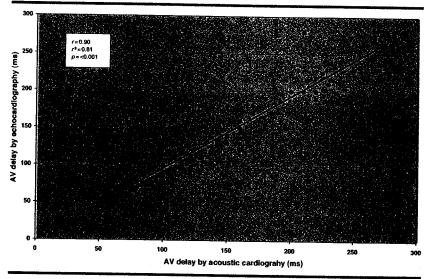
Relationship of recommended atrioventricular (AV) delays obtained through echocardiography and acoustic cardiography (consensus over-read) patient evaluation
